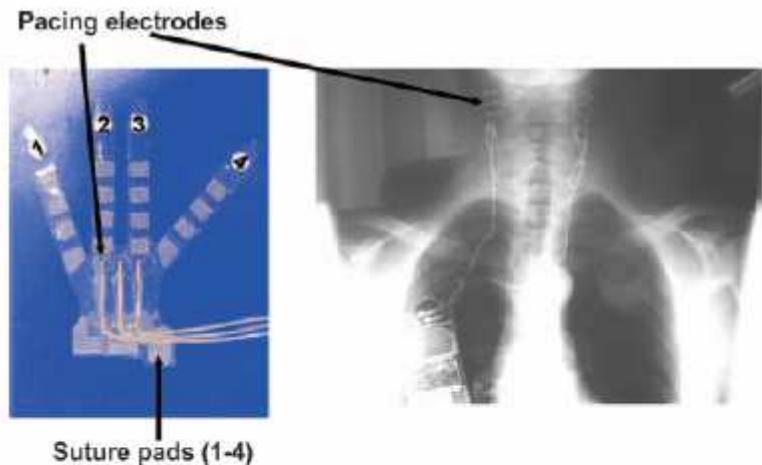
A, Electrode system that is implanted on both carotid sinuses is shown. The adventia is stimulated directly. Pacing electrodes and suture pads of the electrodes are prepared to accommodate placement close to the carotid bifurcation. B, Chest roentgenogram after implantation showing the electrodes in place and the stimulator that is somewhat larger than a conventional pacemaker.
